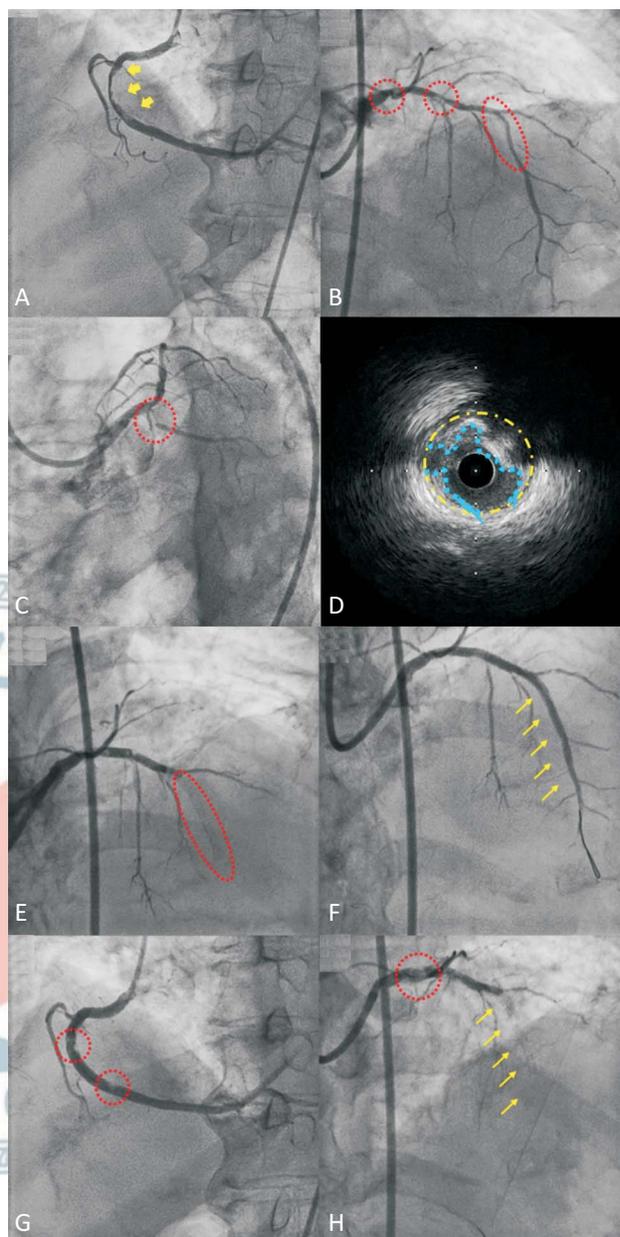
(A) Primary percutaneous coronary intervention (PCI) at the first ST-elevation myocardial infarction (STEMI) event: right coronary artery (RCA) showed a high thrombus burden (yellow arrows). (B) Left anterior descending (LAD) showed diffuse atherosclerosis with 80%-90% segmental stenosis (red circles). (C) Left circumflex artery, a nondominant and small-caliber artery (red circle). (D) Intravascular ultrasound (IUUS) at LAD revealed unstable plaques (blue dash) within the vessel (yellow dash circle) with critical stenosis. (E) Primary PCI at the second STEMI event: LAD showed a large burden of stent thrombosis and total occlusion below the middle part (red circle). (F) LAD showed successful reperfusion (yellow arrows) after balloon dilation and MAT. (G) RCA showed stent thrombosis (red arrows). (H) LAD stent thrombosis recurred soon (red circle) with total occlusion again (yellow arrows).
